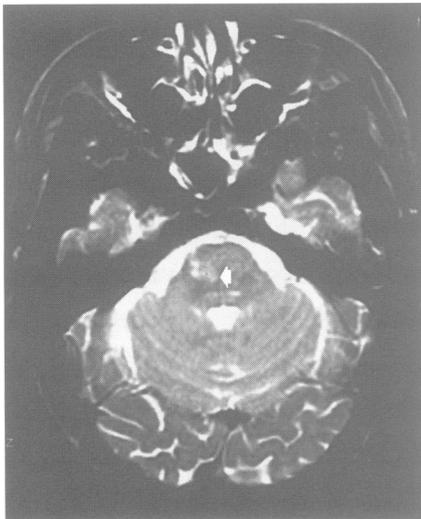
Axial T2 weighted MRI of mid-pons showing infarct in the right lateral basis pontis extending medially.
